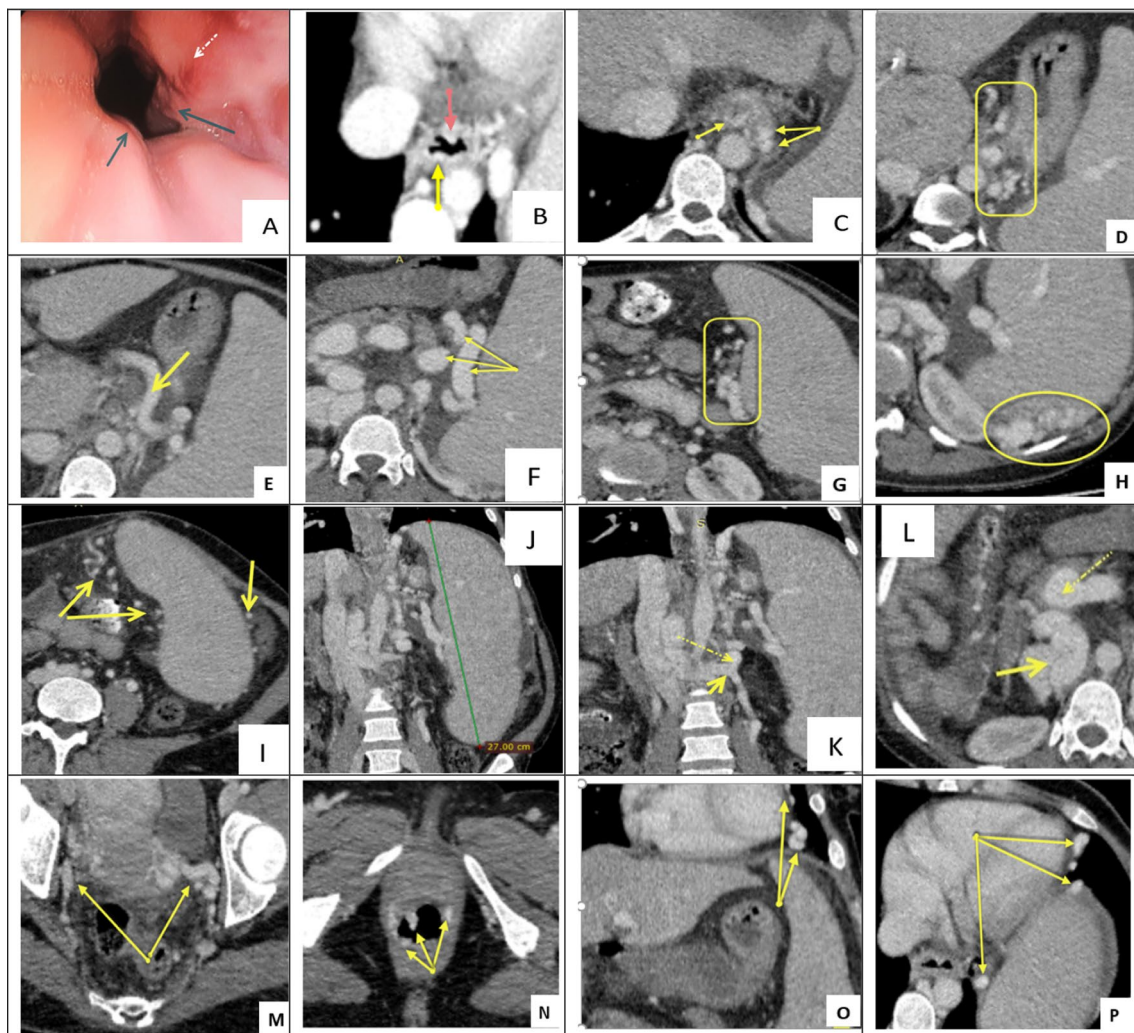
A 42-year-old female patient with chronic liver disease and esophageal varices; A Upper GI endoscopy shows 2 cords of grade 2 (arrows) with a red cherry spot (dashed arrow). Axial CT shows the following; B esophageal varices; upper arrow for grade II and lower arrow for grade I, C paraesophageal varices (solid arrows), D retrogastric (adventitial) varices, (rectangular region), E left gastric (coronary) vein (solid arrow), F dilated tortuous splenic vein (solid arrows), G Hilar splenic varices (rectangular region), H perisplenic (posterior border) varices, I Perisplenic collaterals in a lower pole. Coronal CT displays the following; J Large splenic LS diameter measuring 27 cm, K A lienorenal shunt (dashed arrow) and left renal vein (solid arrow). Axial CT shows, L Retroperitoneal (right pararenal) (solid arrow) and portal vein (dashed arrow) varices, M Paraovarian and pelvic varices (solid arrows), N perirectal varices (solid arrows). O, P Left supradiaphragmatic varices are visible in a coronal CT (O) and axial CT (P)
